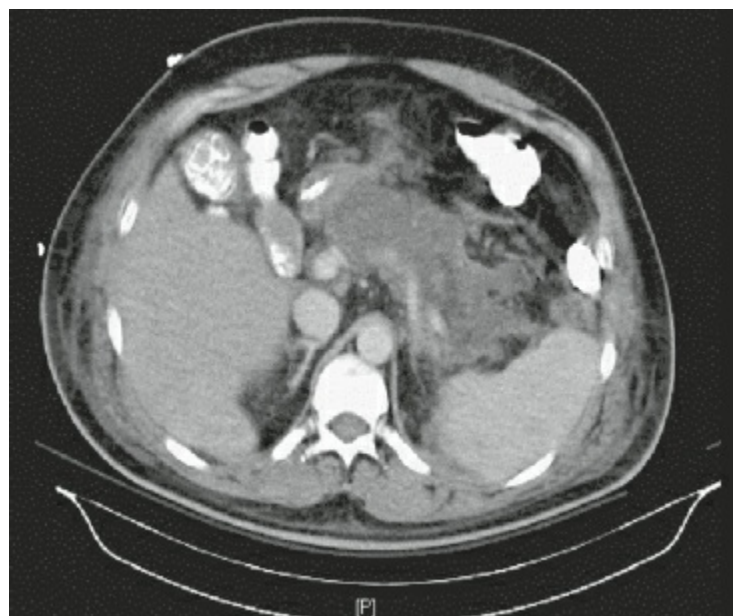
Computed tomography scan of acute necrotizing pancreatitis.
